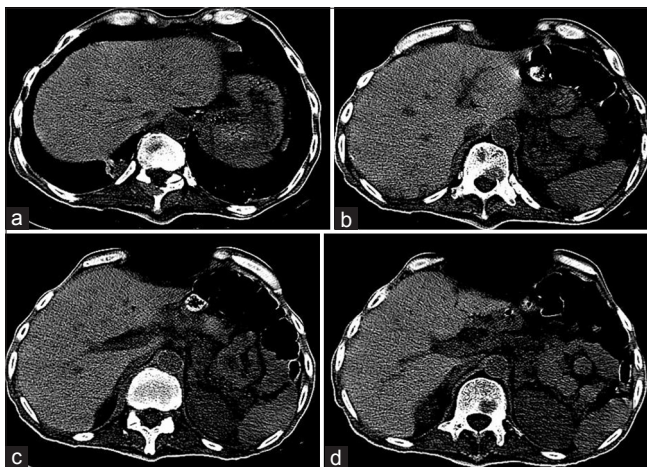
Transverse reconstruction of abdominal computed tomography scan (liver window): No pathological abnormality was diagnosed in the liver
